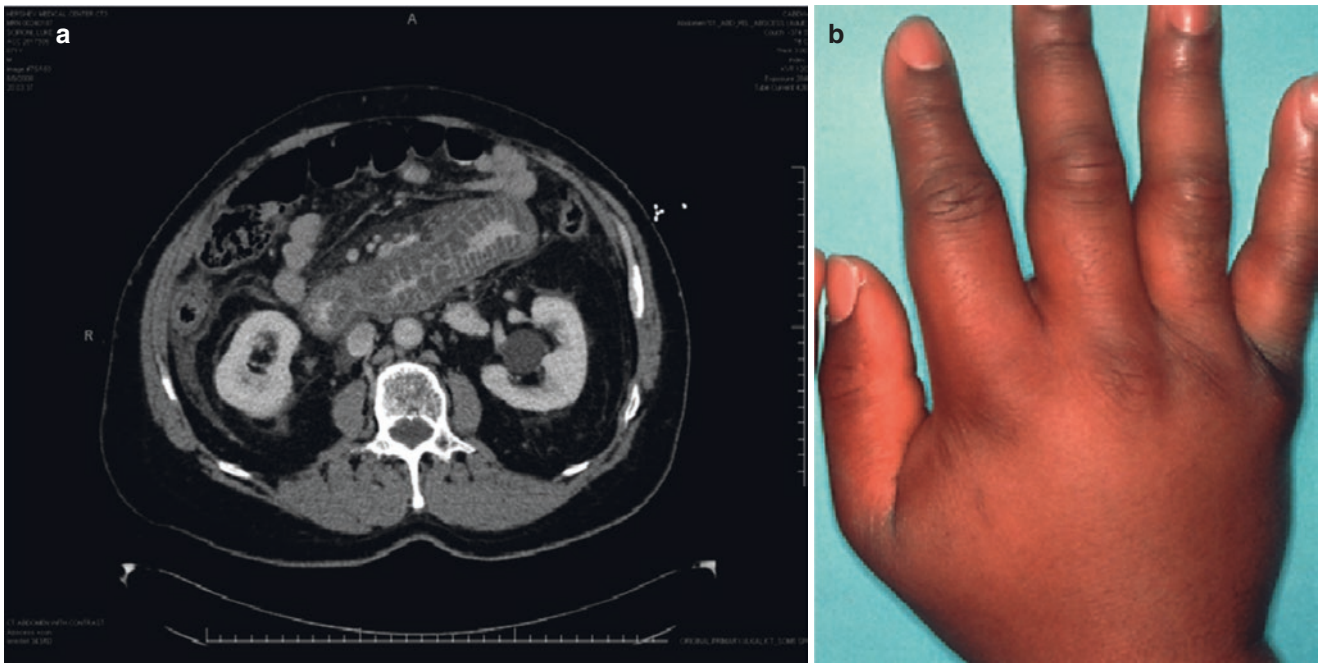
(a) Abdominal CT during the period of pain on presentation to the Emergency Department (ED). (b) Hand swelling on presentation to the ED
